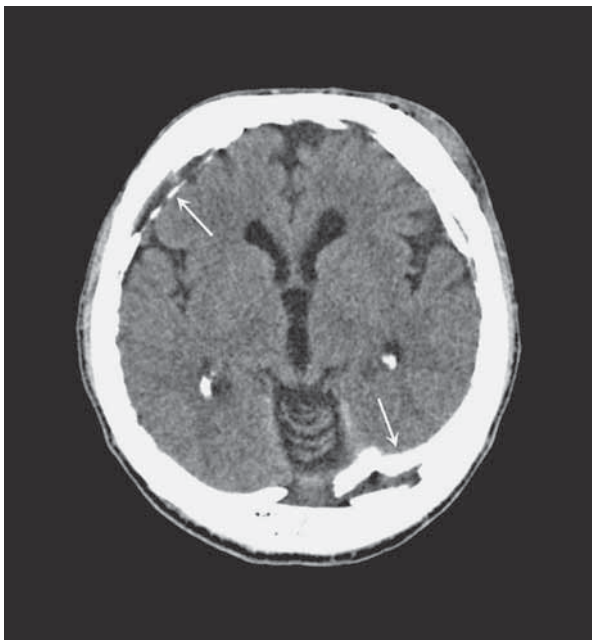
Transverse CT scan: the initial interpretation was bilateral acute subdural hematoma (arrows).
